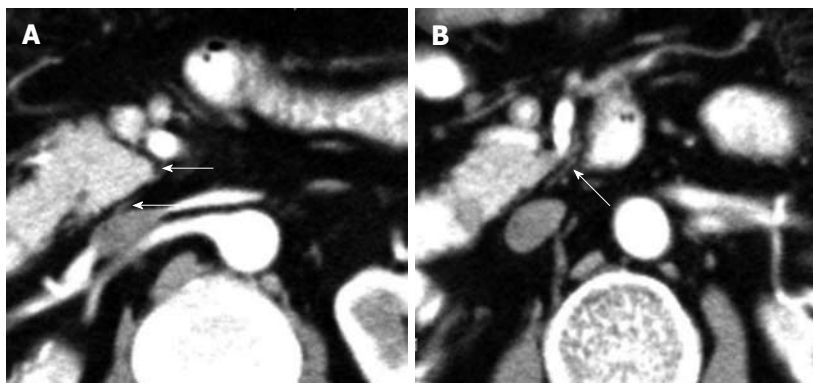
A contrast-enhanced computed tomography shows the plexus (PLX-II) (A, B). The PLX-II extends to the left margin of the uncinate process via the plexus surrounding the superior mesenteric artery (arrows).
